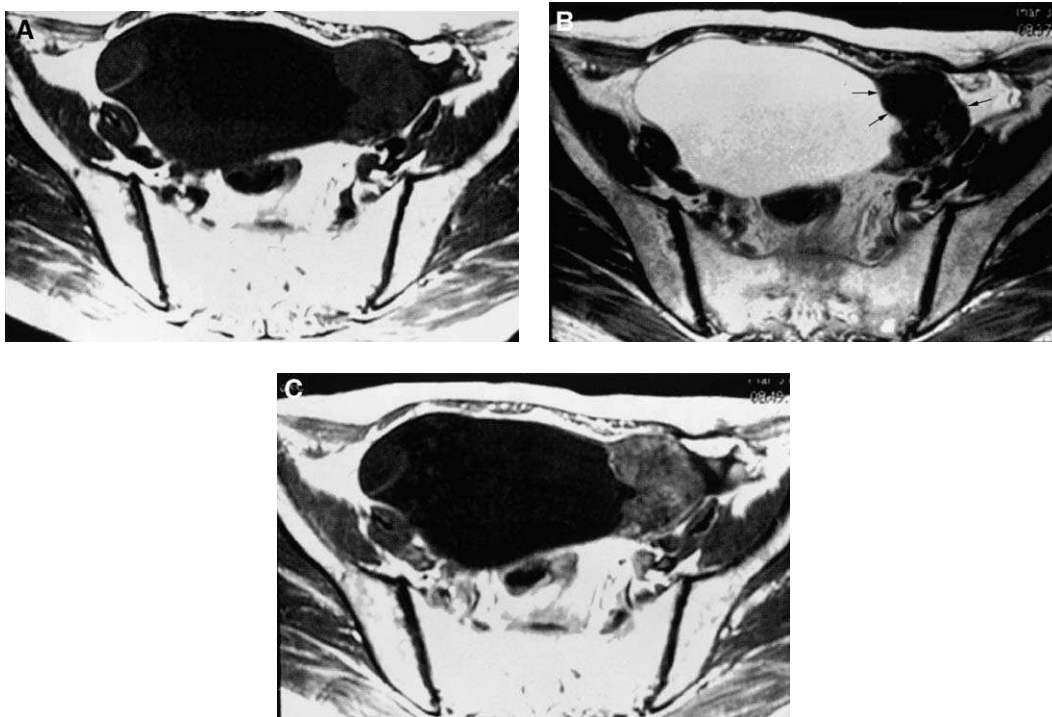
Brenner tumor associated with mucinous cystadenoma. (A) T1-weighted image shows two components that exhibit low signal and intermediate signal intensities. (B) T2-weighted image shows a cystic component (representing the mucinous tumor) and solid tissue (representing the Brenner tumor) that exhibits distinct low signal intensity. (C) Postcontrast image shows a weak enhancement in the solid tissue.
